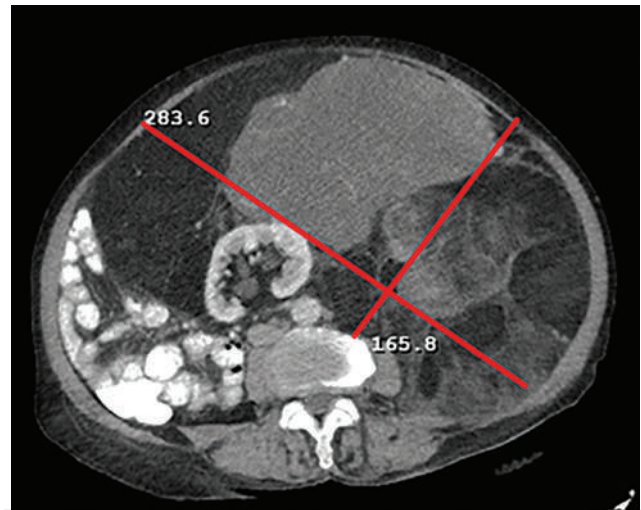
Contrast-enhanced abdominal CT coronal reformat image; a large mass lesion with fatty components originating from the left retroperitoneal area, displacing the left kidney medially and the intestinal loops.
